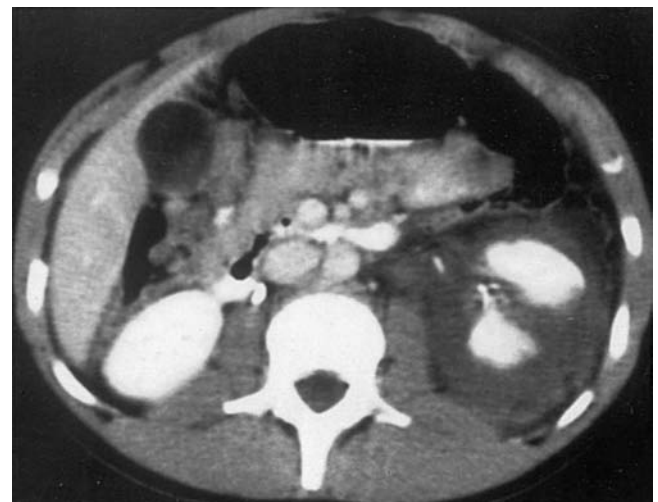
Renal fracture. Computed tomography section of the abdomen shows fracture of the left kidney with moderate subcapsular hematoma.
